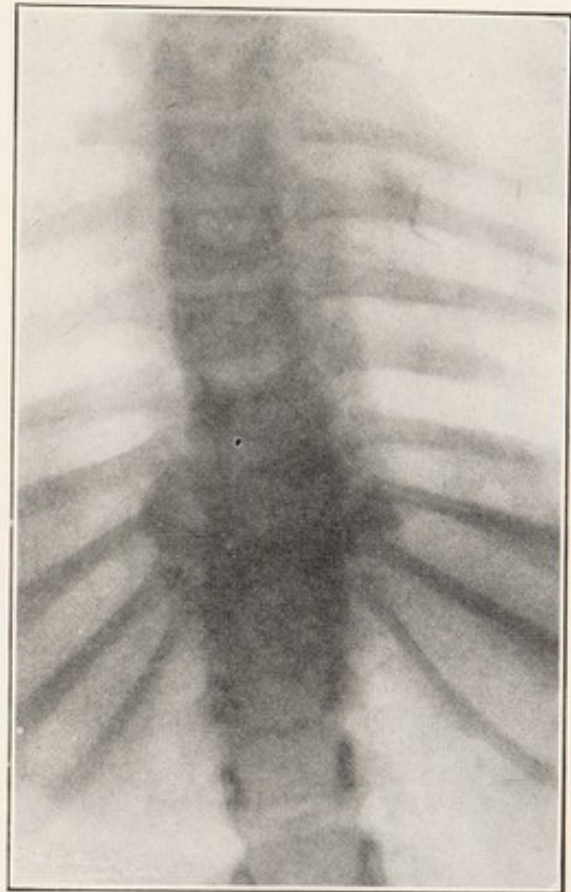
X-RAY SHOWING TUBERCULOSIS OF LOWER DORSAL AREA WITH SPINDLE-SHAPED MASS OF INFLAMMATORY EXUDATE.
